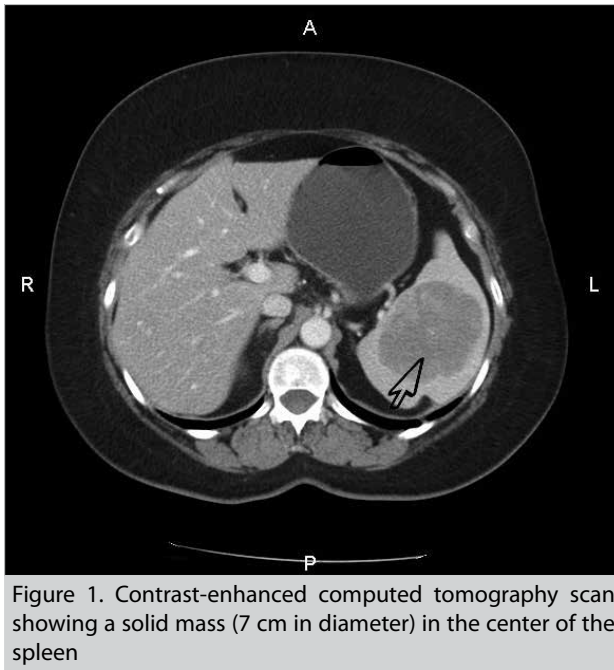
Contrast-enhanced computed tomography scan showing a solid mass (7 cm in diameter) in the center of the spleen
